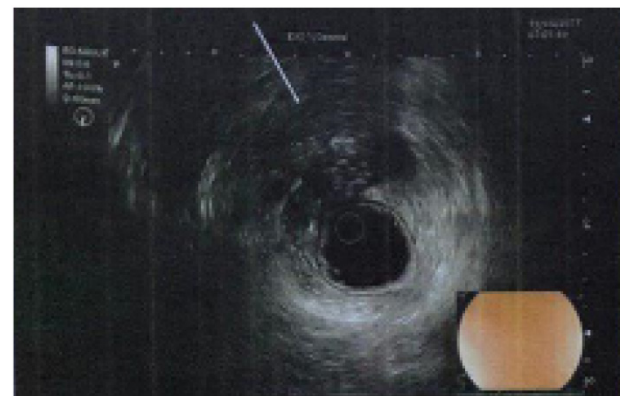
Endoscopic ultrasound that revealed a large heterogeneous mass lesion
